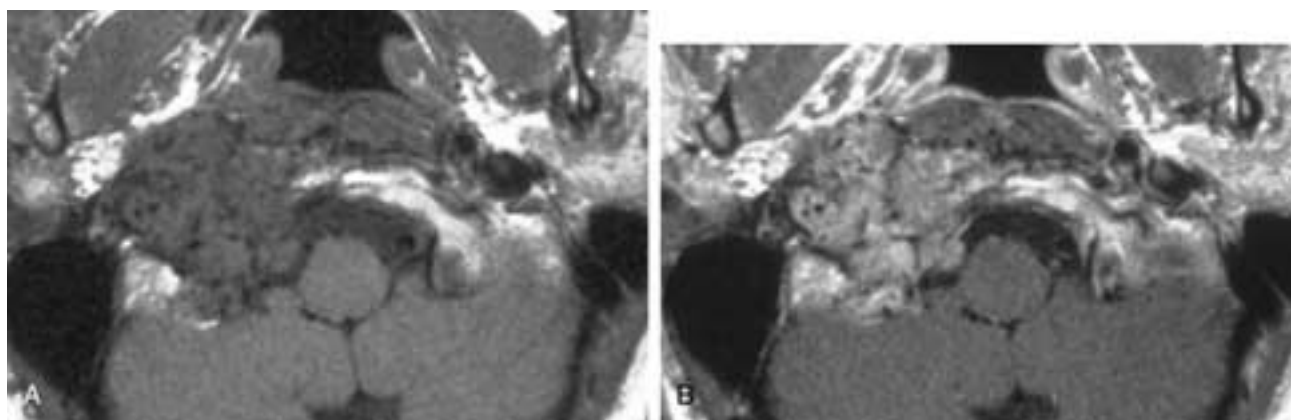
Glomus jugulare tumor. A and B, T1-weighted pre- and postgadolinium images. The heterogeneously hypointense tumor is located in the jugular fossa, extending into the parapharyngeal space and foramen magnum, with temporal bone and clivus invasion. Areas of signal void within the tumor are related to hypertrophic neoplastic vessels. The tumor shows strong enhancement after gadolinium administration.
